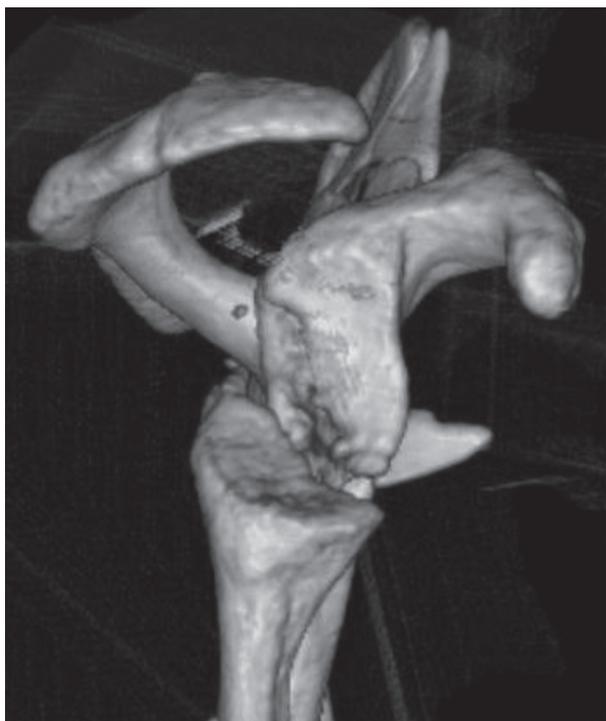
Fracture of the glenoid fossa - distal part, 3D CT reconstruction, lateral view
